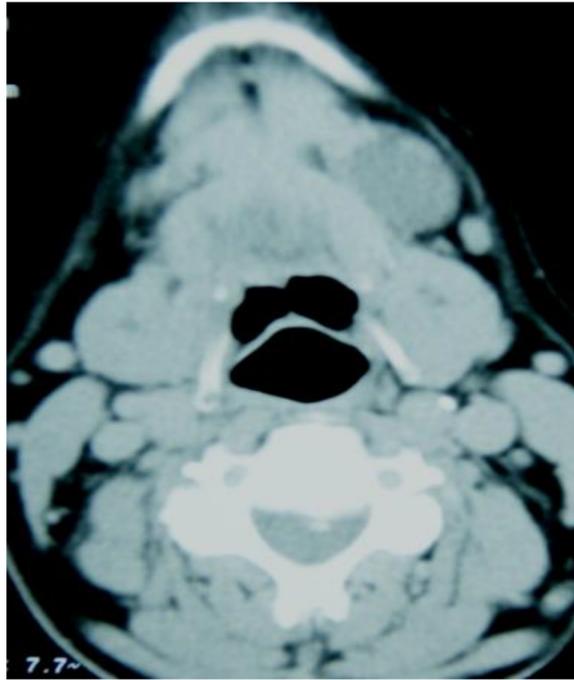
Imaging presentation (CT) showing a cystic mass lesion in left. sublingual space (measured 2×2 cm in midline).
